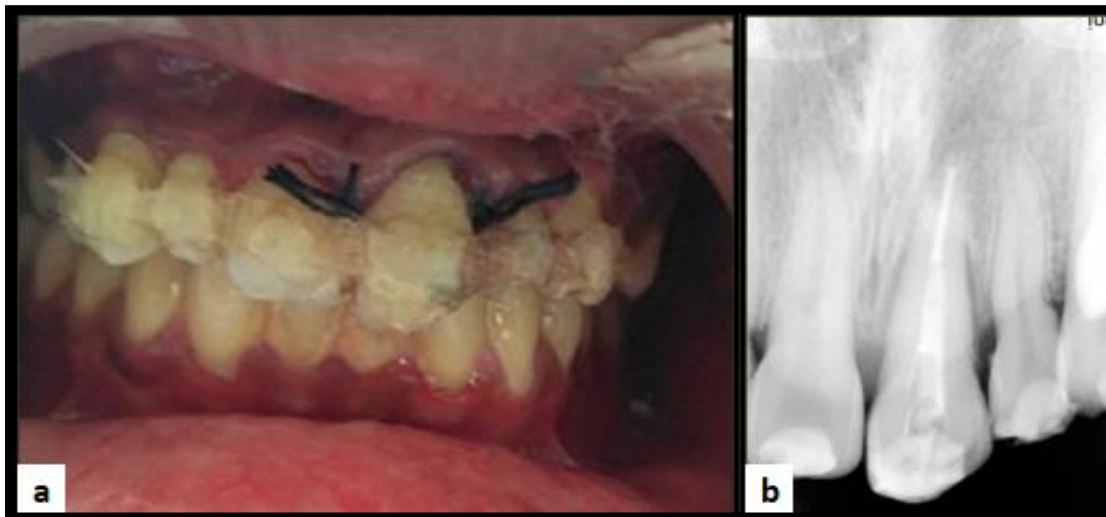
(a) 21 replanted into the socket, sutured and splinted from 13 to 23 using a flexible splinted. (b) radiographic picture immediately after replantation.
